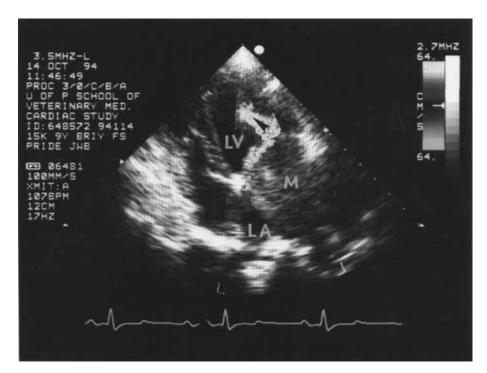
Color Doppler 2-dimensional echocardiogram. Left apical view. The 5-cm-diameter ball-shaped mass (M) in the left atrium (LA) partially obstructs mitral inflow (arrows). LV, left ventricle.
